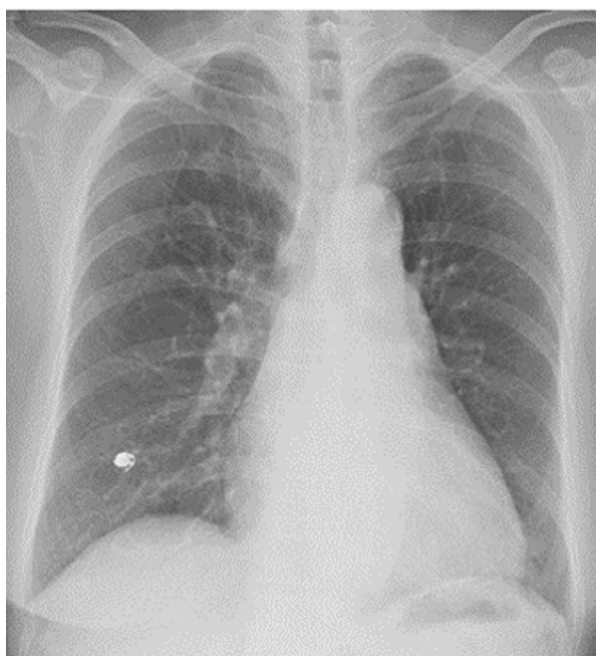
Chest radiograph shows resolution of pseudoaneurysm.
